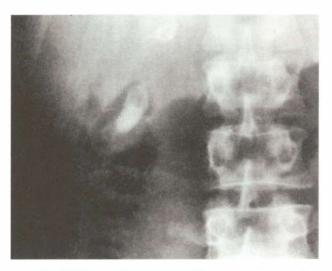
Plain X-ray abdomen showing radio-opaque shadow in the region of gall bladder
